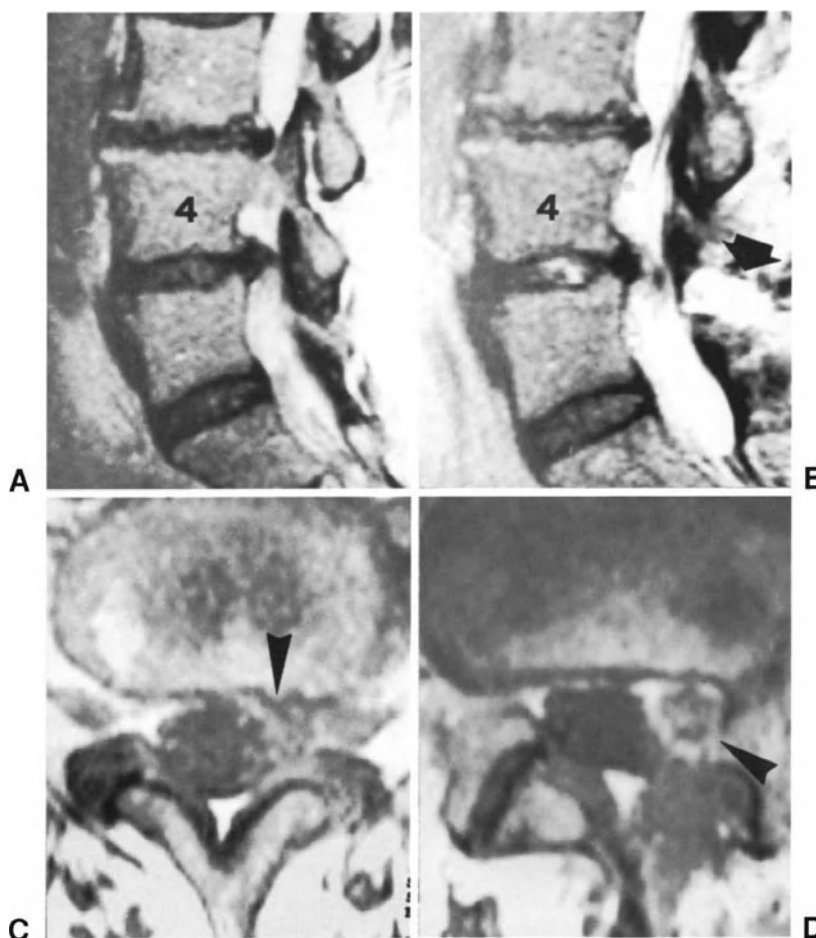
Extrusion of a residual disc fragment after discectomy. The preoperative MRI (A) of this 67-year-old female showed an extruded herniation at L4-L5 level on the left and a small asymptomatic herniation at L3-L4. The patient underwent an L4-L5 discectomy on the left with complete relief of radicular symptoms. Eleven days after surgery she experienced a sudden recurrence of radicular pain on the left. Postoperative MRI, (B) and (C), revealed, at the site of surgery, a tissue of uncertain origin (arrowhead). After gadolinium injection (D), the tissue showed a peripheral increase in signal intensity, whilst the central portion remained hypointense (arrowhead). The arrow in (B) indicates the hyperintense tissue present at the site of the surgical approach.
